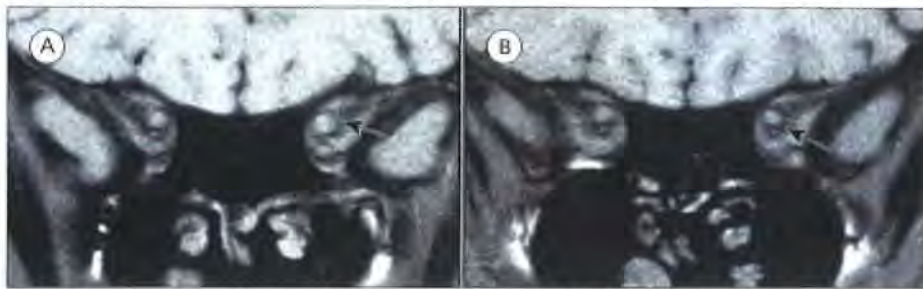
Coronal fast FLAIR images through the orbits. (A) During an attack of left optic neuritis and (B) 12 months after the episode of left optic neuritis. The affected nerve is swollen acutely and atrophic 1 year later (arrows).
